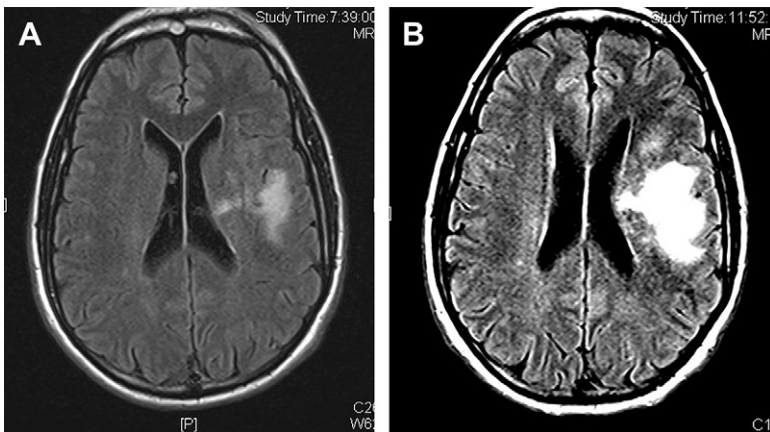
Rapid progression of progressive multifocal leukoencephalopathy with characteristic white matter abnormality that does not enhance (not shown) in a patient 1 year after HCT for AML. Eighteen days separate (A) from (B), both FLAIR MRI images. Patient was JC virus positive in CSF.
